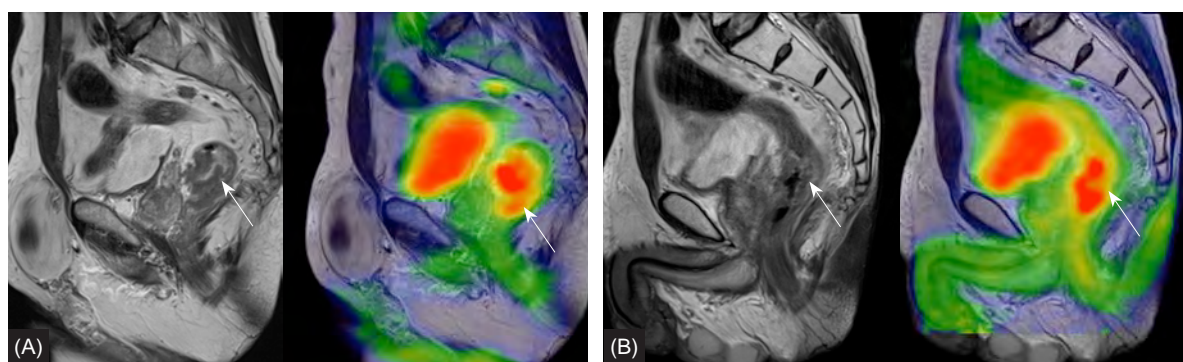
Poor response to preoperative chemoradiotherapy (CRT). (A) Preoperative positron emission tomography/magnetic resonance imaging (PET/MRI). (B) Post-CRT PET/MRI. Arrows indicate the rectal tumour.
